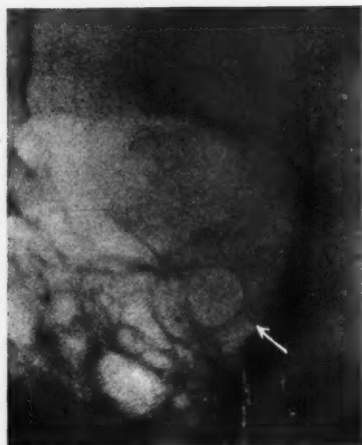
Roentgenogram of the optic canal, after the method of Rhese-Goalwin. Enormous dilatation due to endocranial increase of pressure.
